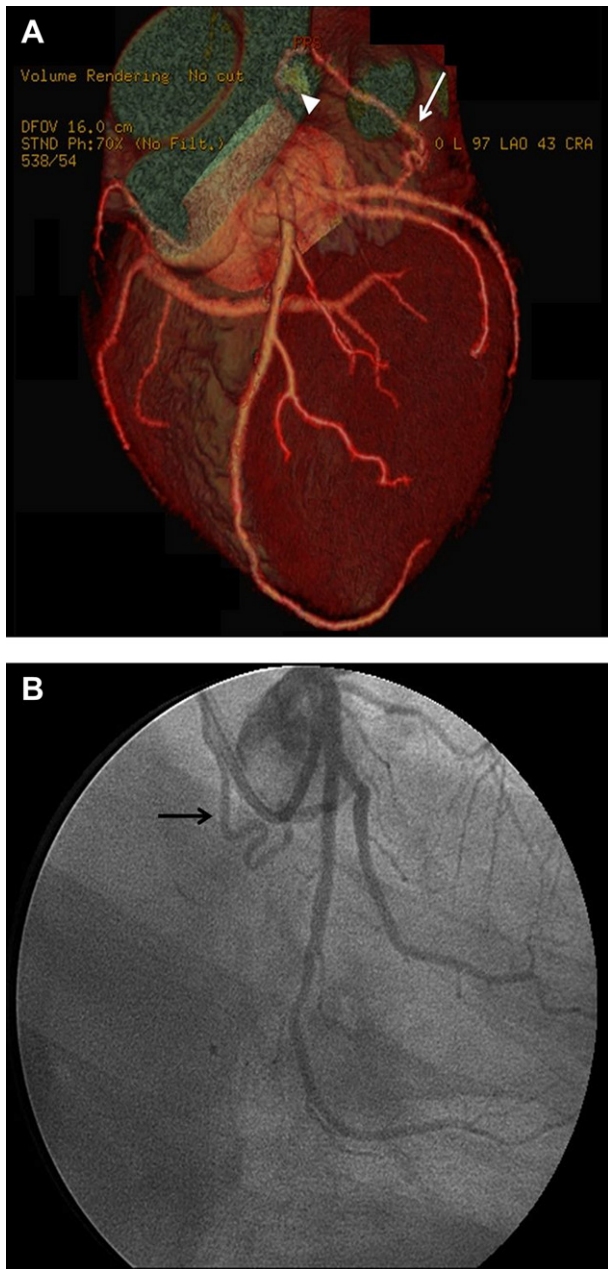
(A) Volume rendering cardiac computed tomography shows a tortuous artery (arrow) originating from the left circumflex artery coursed to the outpouching of the left atrium (arrowhead). (B) Left coronary angiography proves the fistula (arrow). CAU = caudal; CRA = cranial; DFOV = dual field of view; LAO = left anterior oblique; STND = standard.
